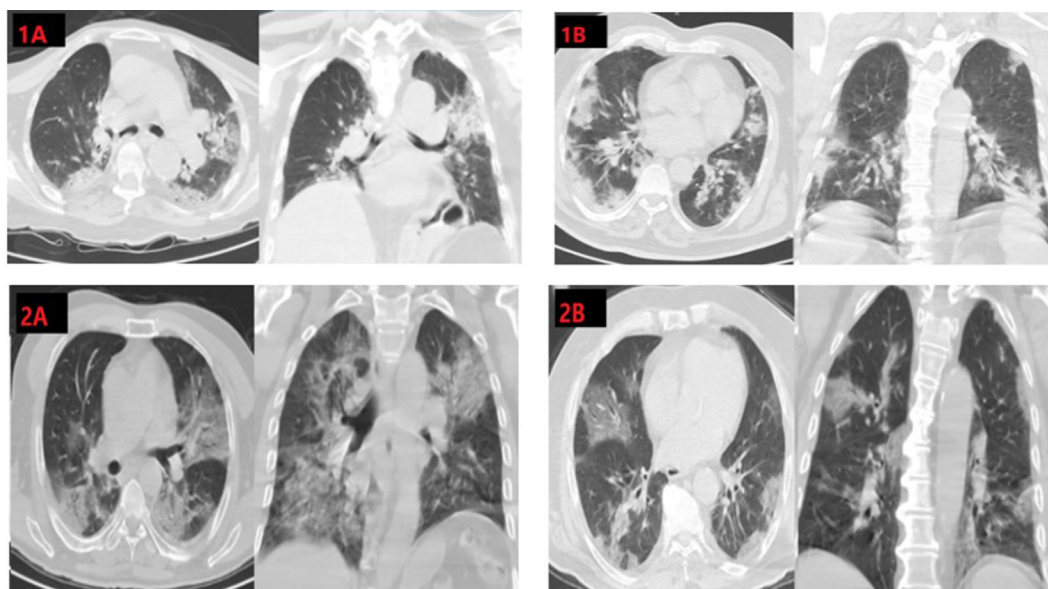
Features of demographic and Chest CT findings of RT-PCR positive and negative patients. 1A: 69 years old, non-survivor male patient, RT-PCR test was negative, Chest CT: multifocal peripheral consolidations in the left lung upper lobe and both lung lower lobes and focal ground glass opacities (GGO) appearance in the left lung upper lobe were observed. 1B: 74 years old, survivor, male patient, RT-PCR test was negative, her wife's RT-PCR test was positive, Chest CT: Widespread sub pleural GGO and consolidation areas are observed in both lungs. 2A: 62 years old, non-survivor, male patient, RT-PCT test was positive, Chest CT: In the lung parenchyma areas, there are common patch-style GGO and consolidated areas in the periphery. 2B: 80 years old, non-survivor, male patient, RT-PCR test was positive, Chest CT: Diffuse GGO containing air bronchograms were observed in both lungs.
